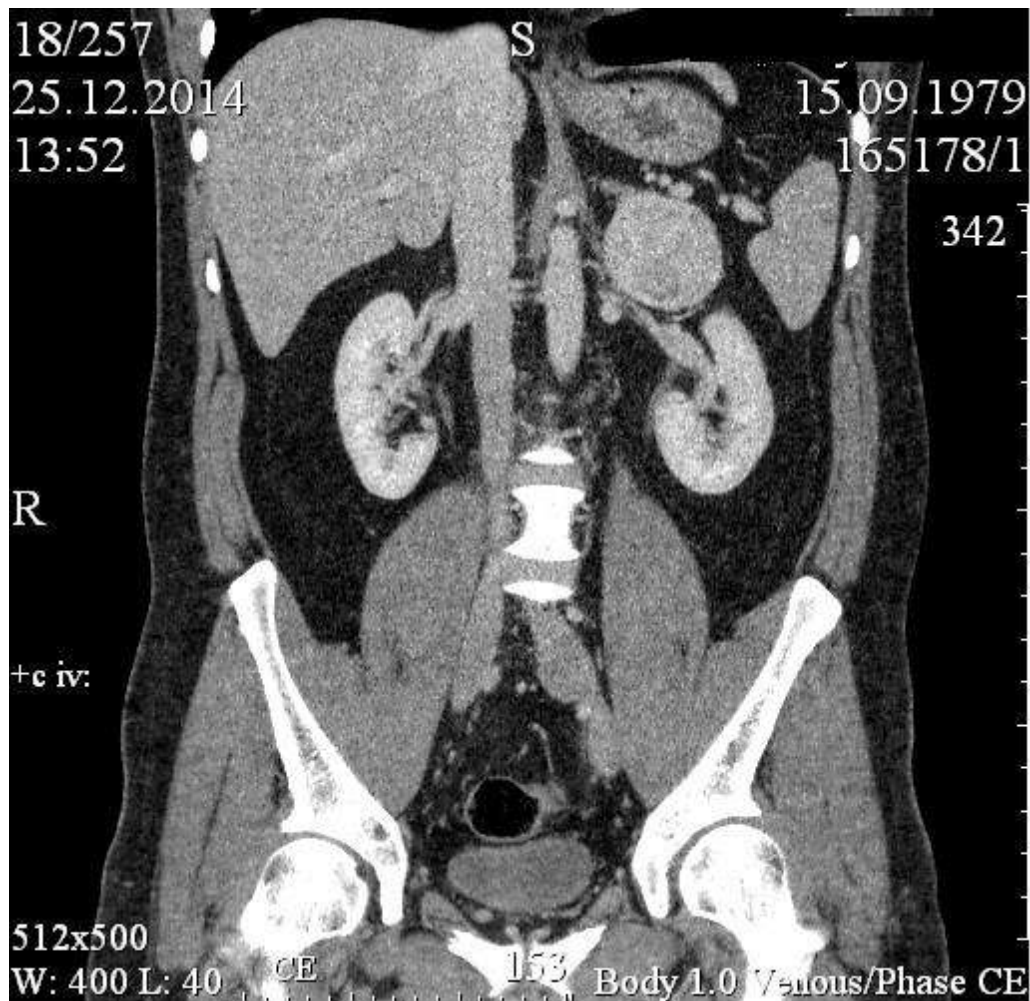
Pheochromocytoma of the left adrenal gland. Computed tomography, venous phase of the study.
